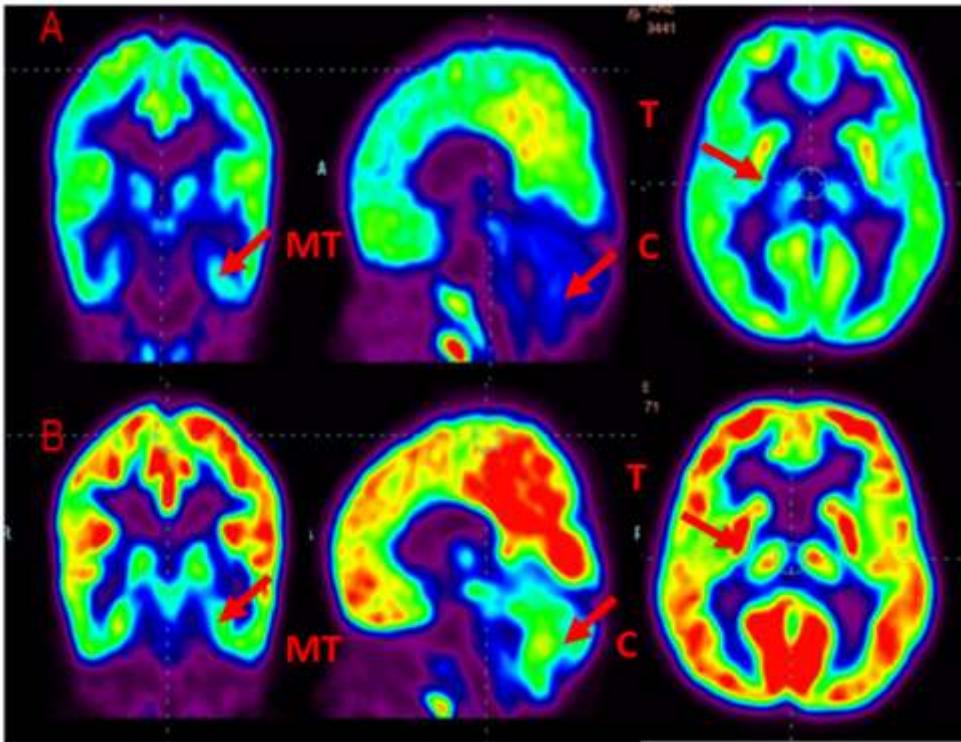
Comparative PET CT scan showing improved brain metabolism. Before stem cell therapy, PET CT scan showed severely reduced metabolism in the bilateral thalamus, medial temporal cortex and cerebellum. Post stem cell therapy, it showed improved metabolism in the bilateral thalamus, medial temporal cortex and cerebellum
